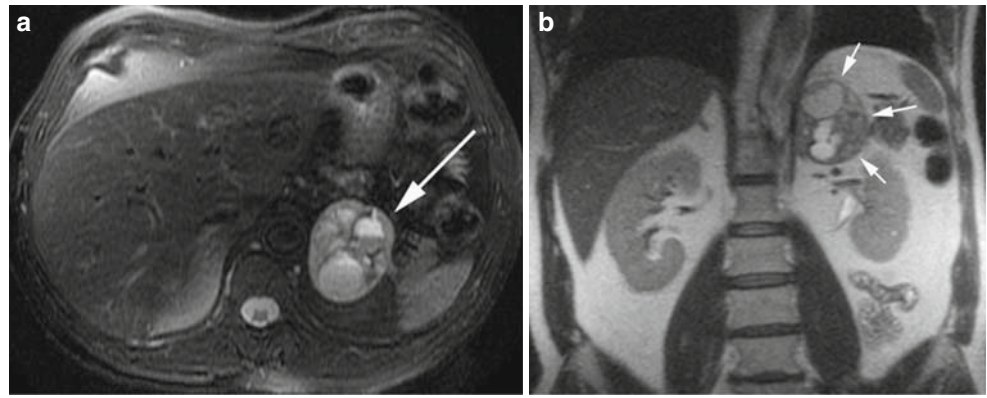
Imaging of pheochromocytoma. A 68-year-old man with incidentally found left suprarenal mass. Axial T2-weighted image from an MRI (a) demonstrates a complex cystic and solid rounded supra-adrenal mass. The foci of T2 hyperintensity indicate the cystic areas. Coronal HASTE image (b) shows the same findings. This lesion demonstrated persistent, patchy areas of enhancement after contrast administration (not shown)
